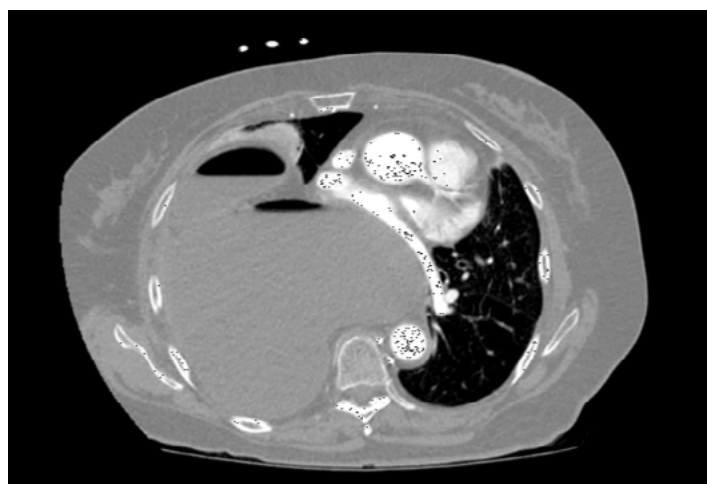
Computed tomography showing mass effect from large intrathoracic gastric volvulus causing significant cardiac compression and mediastinal displacement (axial view).
